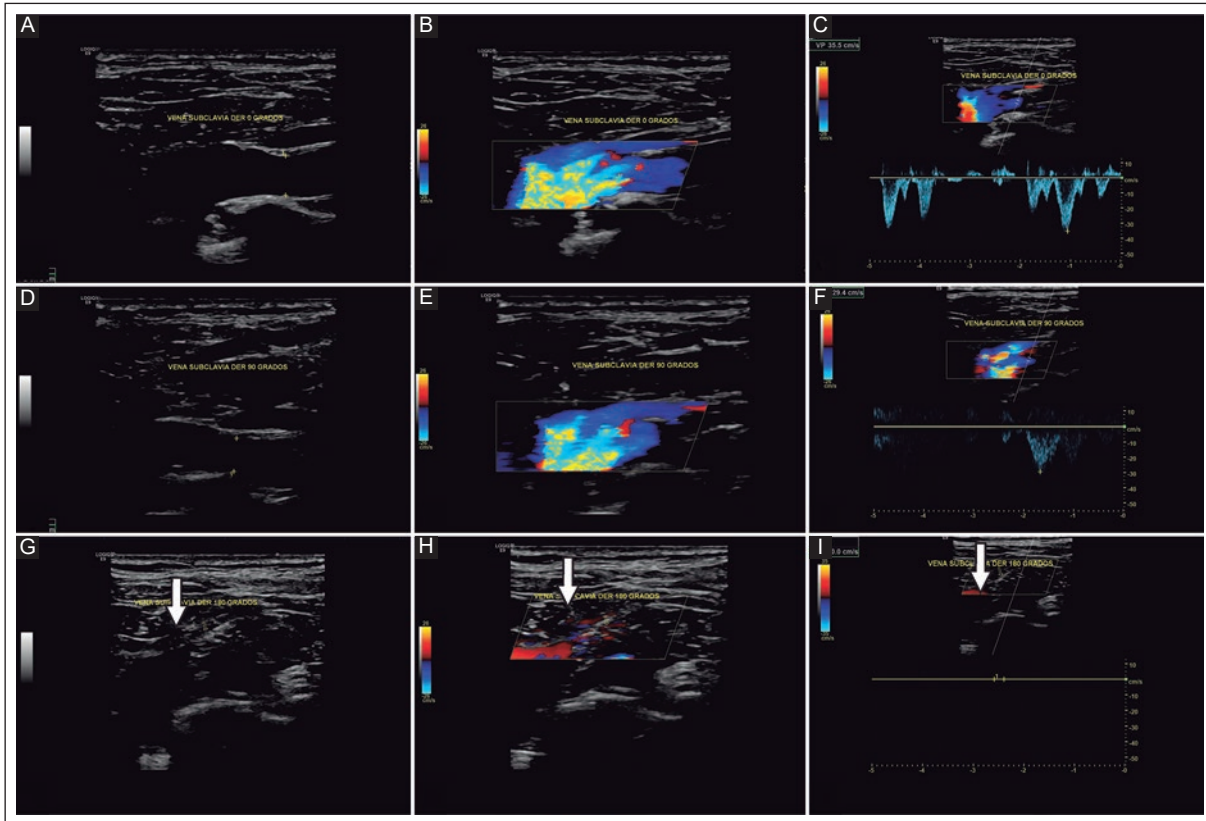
Abnormal US duplex Doppler in a 34-year-old male patient with venous TOS. The subclavian vein was assessed at 0° with a normal diameter (A), patency (B), and flow velocity (C); with dynamic maneuvers at 90°, a decreased diameter (D), patency (E), and flow velocity (F) were observed, and at 180° a complete reduction in diameter (G) (arrow) absent patency (H) (arrow) and flow velocity (I) (arrow) were observed.
